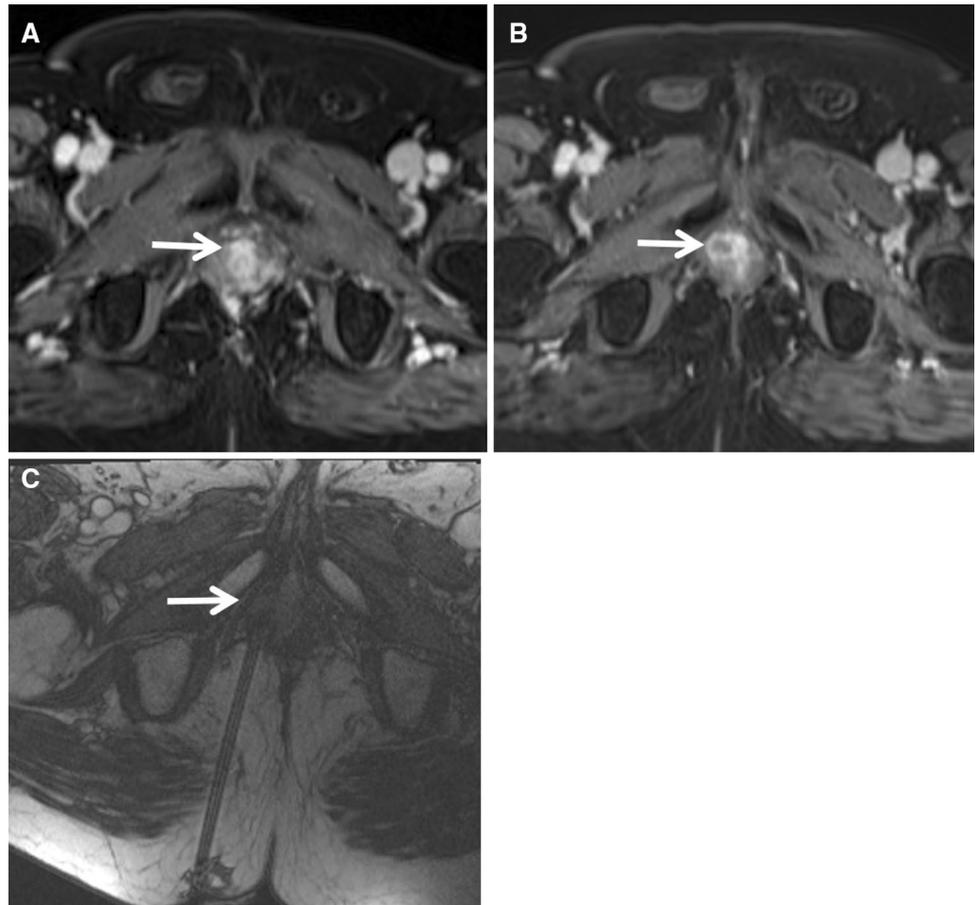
Anterior compartment recurrence. A 77-year-old male with history of rectal adenocarcinoma status post-abdominoperineal resection. a Surveillance MRI shows normal prostatic enhancement (arrow). b Surveillance MRI 3 years later demonstrates an enhancing nodule. This nodule was biopsied with MR-guidance (c), and the pathologic diagnosis was rectal adenocarcinoma
